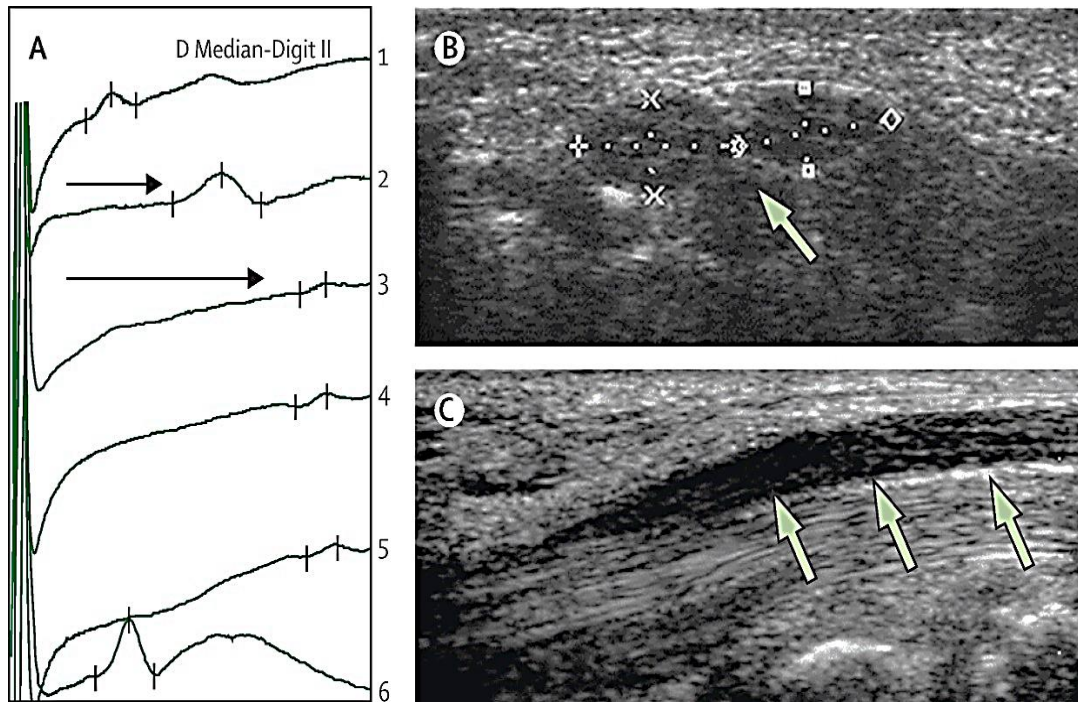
Electrophysiological and ultrasound features of CTS. (A Nerve conduction study. B Transverse ultrasound image of bifid d median nerve. C Longitudinal ultrasound image of median nerve).
